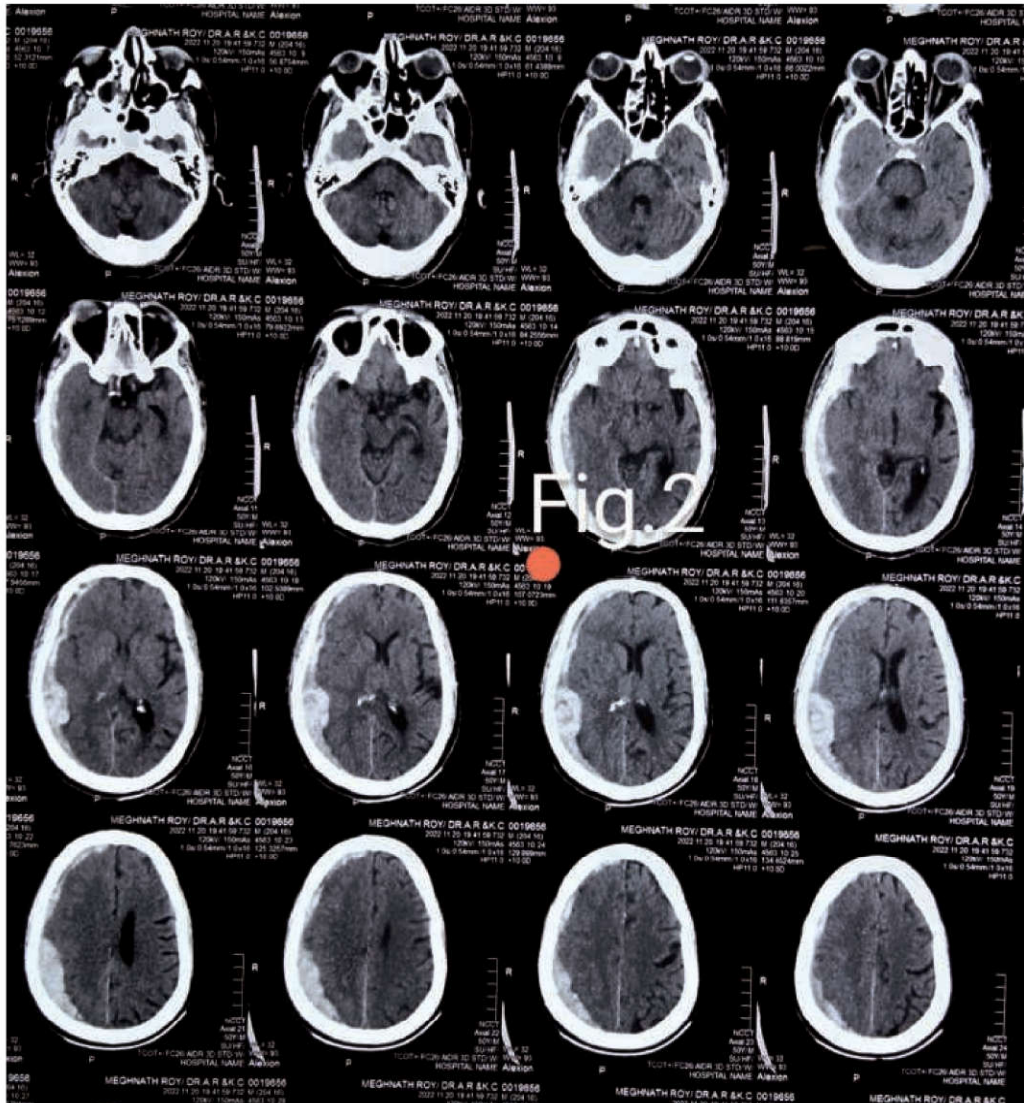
CT scan after surgery.
